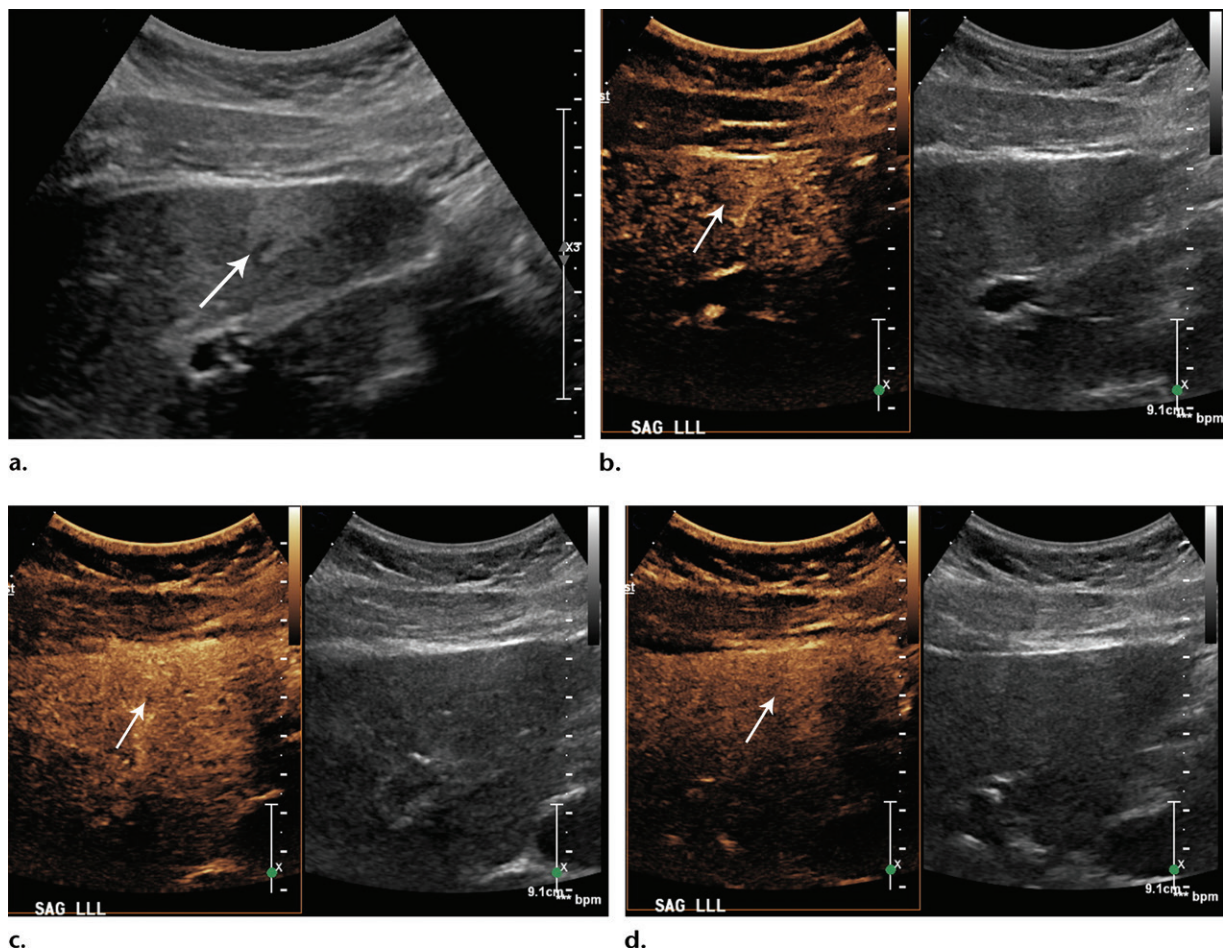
Focal fat discovered incidentally in a 14-year-old girl at US performed to determine the cause of abdominal pain of 2 months' duration. (a) Sagittal gray-scale US image shows a focal echogenic lesion (arrow) in the left liver lobe. (b–d) Dual-screen sagittal CEUS (left) and gray-scale US (right) images show the lesion (arrow) to be isoenhancing relative to the liver parenchyma during the arterial (b), portal venous (c), and late venous (d) phases. MR imaging was not needed to confirm the diagnosis. Focal fat is a benign entity with enhancement similar to that of the adjacent liver parenchyma.
